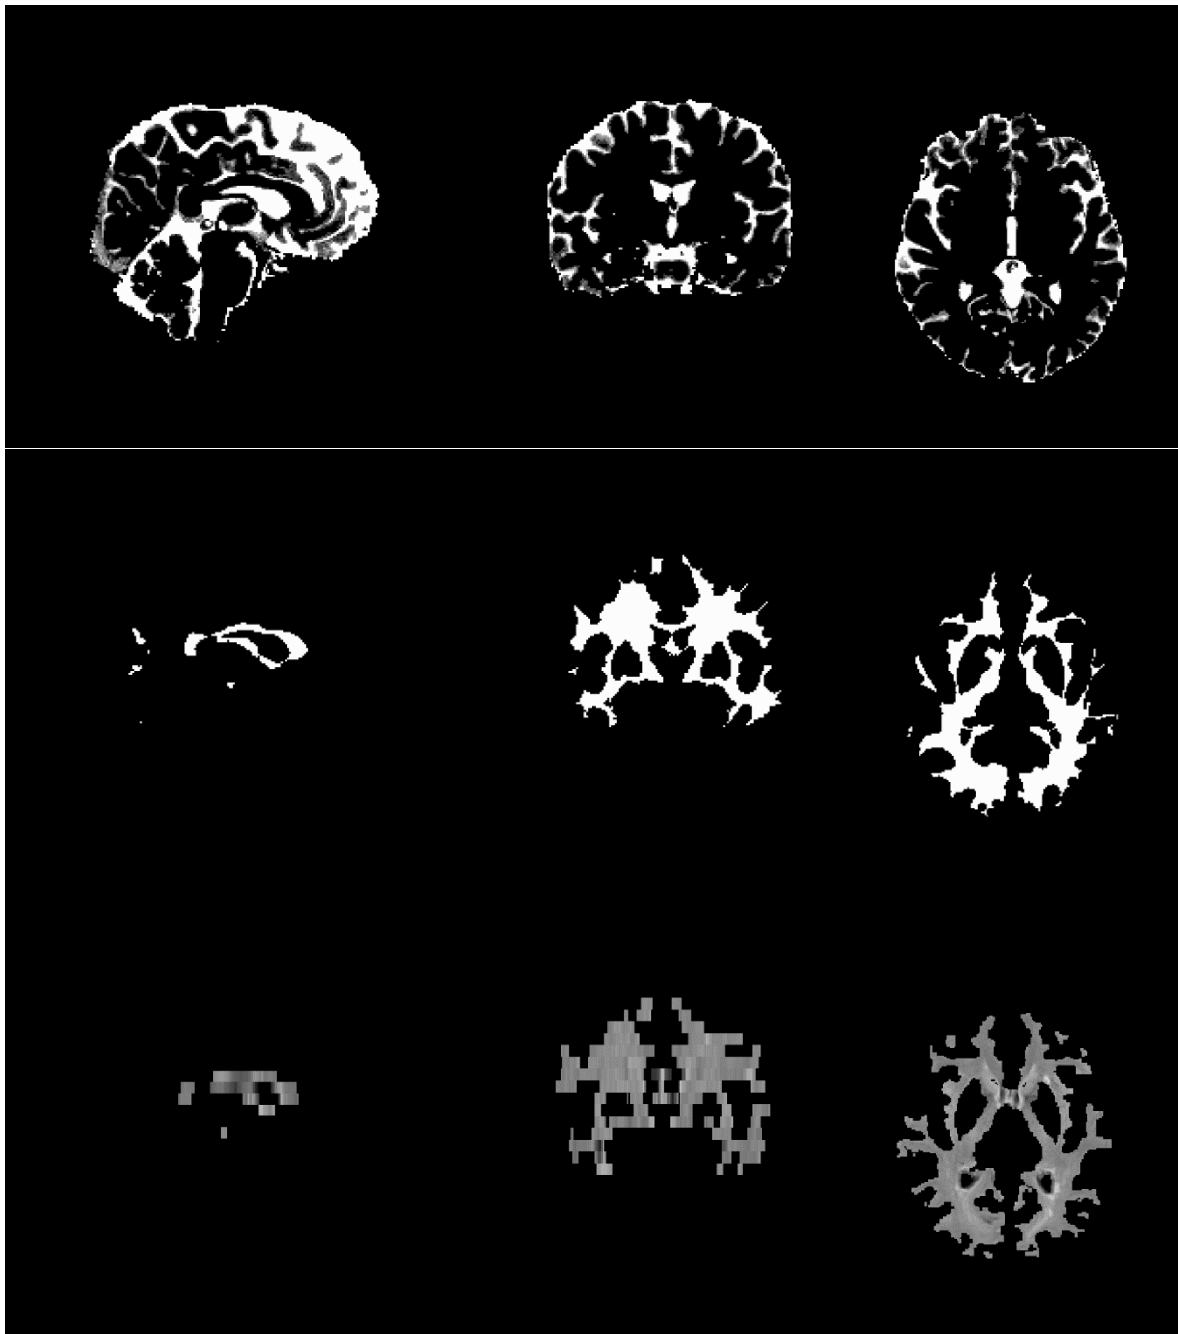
Binary image of the CSF mask (top panel); binary mask created using the “make_bianca_mask” command (central panel); bianca mask registered and applied to the FLAIR image (bottom panel).
